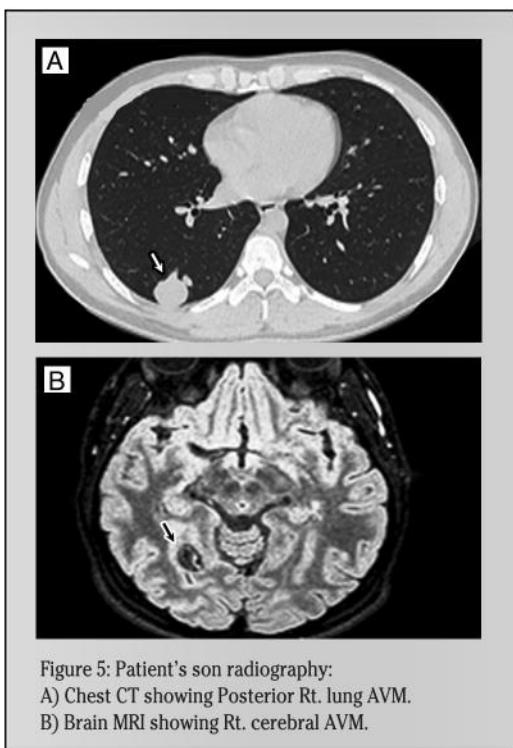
Patient's son radiography:
